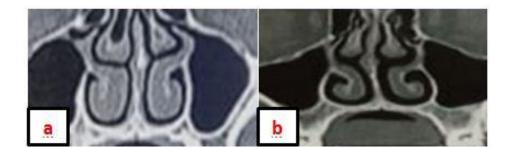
CT coronal section showing the effect of montelukast on size of inferior turbinate (a) before therapy, (b) after therapy.
